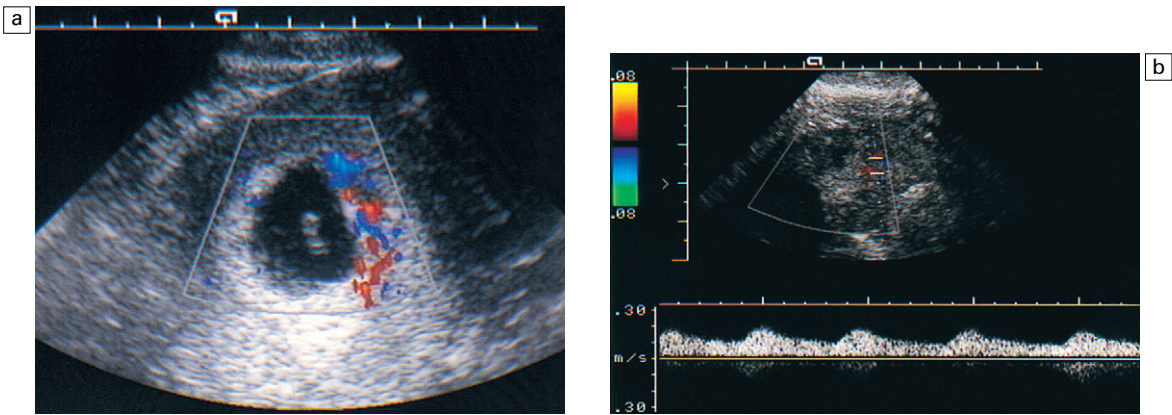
(a) Normal colour flow pattern in the trophoblast of a normal 7-week intrauterine pregnancy. (This patient subsequently had a termination of the pregnancy.) (b) Vascular trophoblast in the adnexal region. Colour and spectral Doppler demonstrating low-resistance flow, implying active trophoblast and suggesting the need either for administration of methotrexate as medical treatment or operative intervention.
